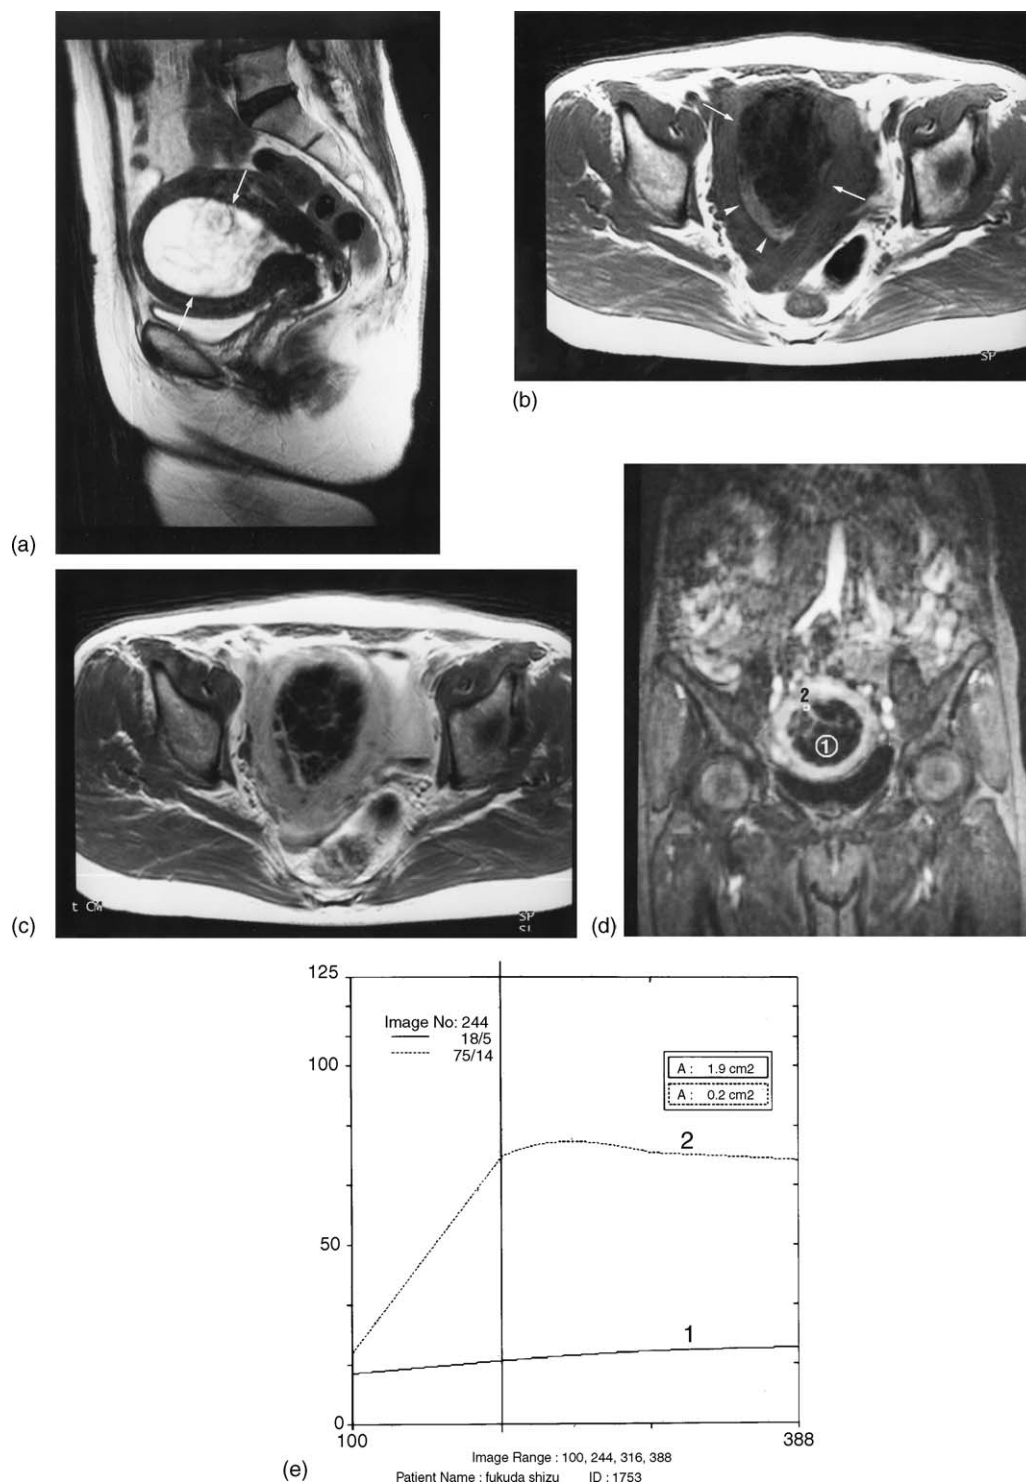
Case 1: (a) on sagittal T2-weighted MR image (4500/120), a large heterogeneous mass (arrow) is seen in the endometrial cavity; (b) on axial T1-weighted MR image (500/12), the endometrial mass is seen as heterogeneous hypointense (arrow) and partial hyperintense (arrowhead) area representing hemorrhagic foci; (c) Gd-enhanced axial T1-weighted image (500/12) in the equilibrium phase shows enhancing septum and mural nodule; (d) 3D Gd-dynamic study (4.0/1.6; flip angle 30) shows septum-like and mural nodule enhancement (early peak and plateau) [1] in the hypovascular mass [2].
